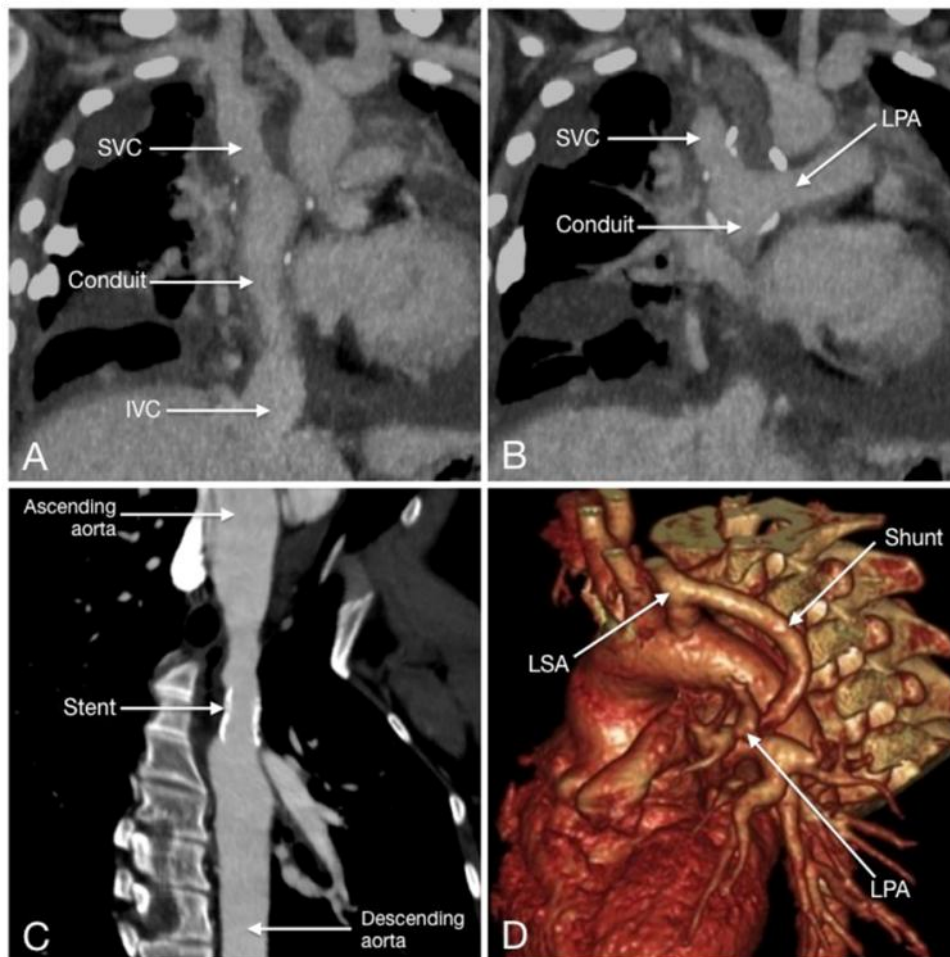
CT after CHD surgery and intervention. A and B, CT images demonstrating a patent conduit that connects the inferior vena cava with the pulmonary arteries and superior vena cava in a Tricuspid atresia patient who underwent Fontan procedure. Pericardial and pleural effusions are also seen. C, Curved planar reformation CT after stent implantation for aortic coarctation. D, Volume rendered image showing a left modified Blalock-Thomas-Taussig shunt (patent prosthetic graft interposed between the left subclavian artery and ipsilateral pulmonary artery) in a Tetralogy of Fallot patient. SVC = superior vena cava, IVC = inferior vena cava, LPA = left pulmonary artery, LSA = left subclavian artery.
